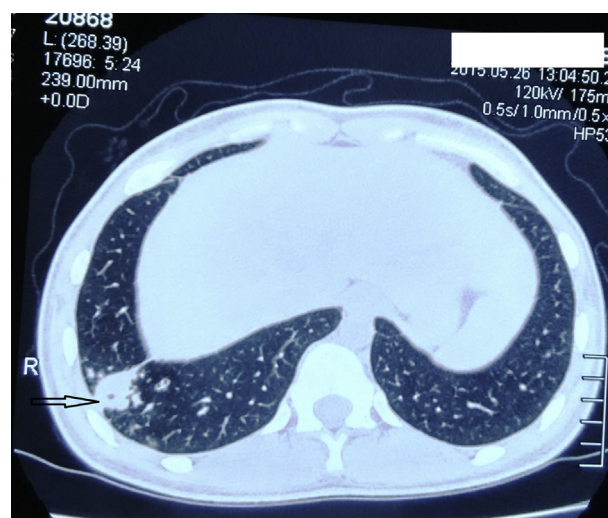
Axial section CT-thorax showing a nodule with central cavitation.
